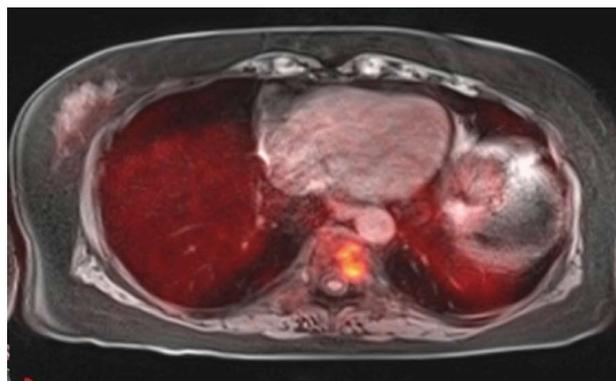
A 63-year-old female with renal failure and abnormal serum protein electrophoresis. Positron emission tomography-magnetic resonance imaging revealed focal abnormal heterogeneously T1 hypointense and T2 hyperintense lesion with corresponding increased FDG uptake. Lesion biopsy was positive for multiple myeloma. FDG: ^{18}F -fluorodeoxyglucose.
